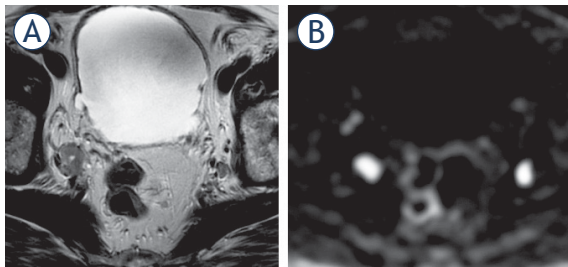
77-yr-old man with PSA = 38.2 ng/ml. Enlarged nodes bilaterally consistent with metastatic involvement on T2 weighted imaging (T2WI) (A), more conspicuous on diffusion weighted imaging (DWI) (B).
